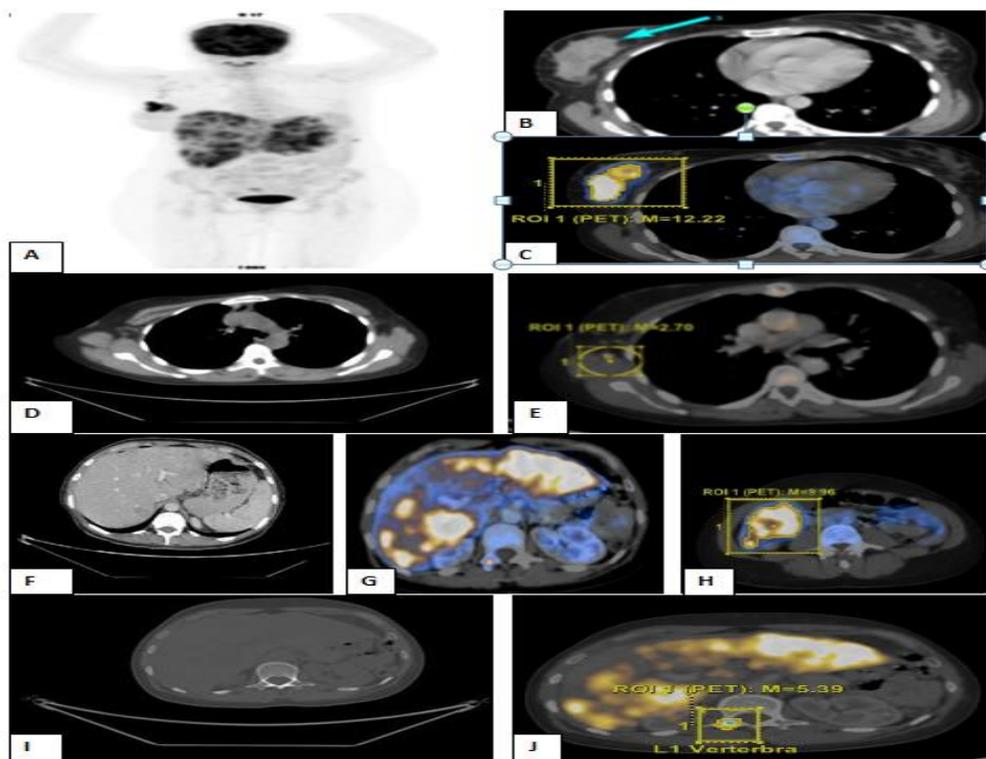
A 36years old female patient presented with recently diagnosed breast cancer. A: whole –body PET MIP picture revealed active breast cancer and hepatic lesions. B &C: axial CECT scan and fused PET /CT scan of the chest revealed a large lobulated mass with heterogeneous enhanced soft tissue mass lesion noted at upper outer quadrant of right breast measuring about 6.6x3.3 cm and achieving SUV max up to 12.22. D&E: axial CECT scan and axial fused PET/CT scan revealed multiple enlarged metabolically active right axillary and pectoral lymph nodes the largest and most active is seen measuring about 14x9mm and achieving SUV max up to 3.02. F,G&H: axial CECT scan and axial fused PET/CT scan of the abdomen revealed multiple hyper metabolic focal lesions seen all over the hepatic lobes largest and most active one at left lobe is noted measured about 2x1cm and achieving SUV max up to 9.97, not appreciated in CT image alone . I&J: axial CECT and fused PET /CT scan revealed hyper metabolic active lytic osseous lesion at right transvers process of L1 vertebra achieving SUV max 5.39....The patient was stage IIIA(T2 N2 M0)by CT and upgrade to stage IV (T2 N2 M1) by PET/CT.
